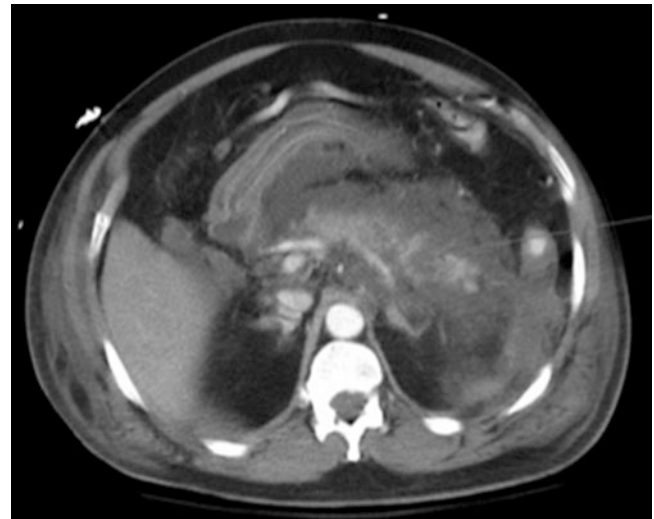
CT scan demonstrating peripancreatic edema and areas of nonenhancing pancreas consistent with necrosis
